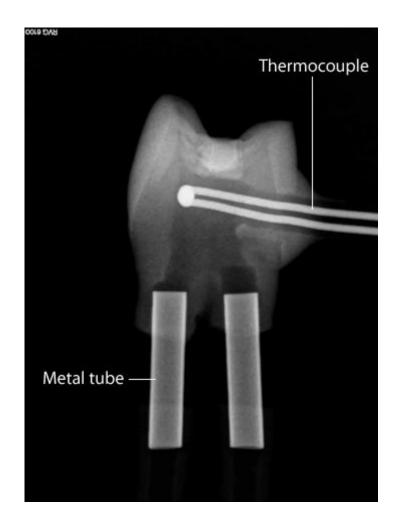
X-ray of the premolar with a thermocouple and a metal tube.
